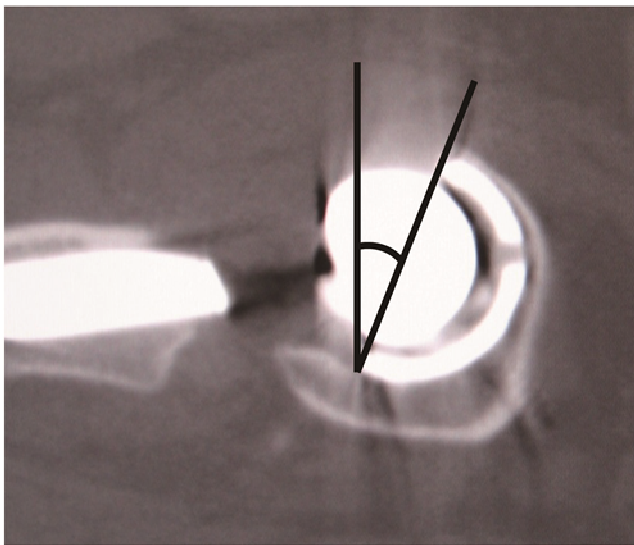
Method for measuring cup anteversion on CT scans
